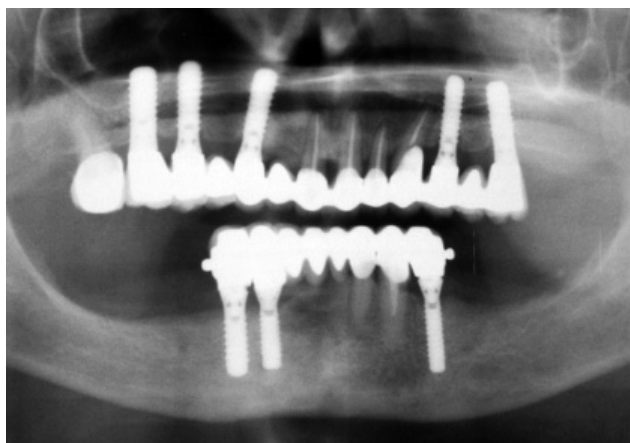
Radiographic view after treatment
